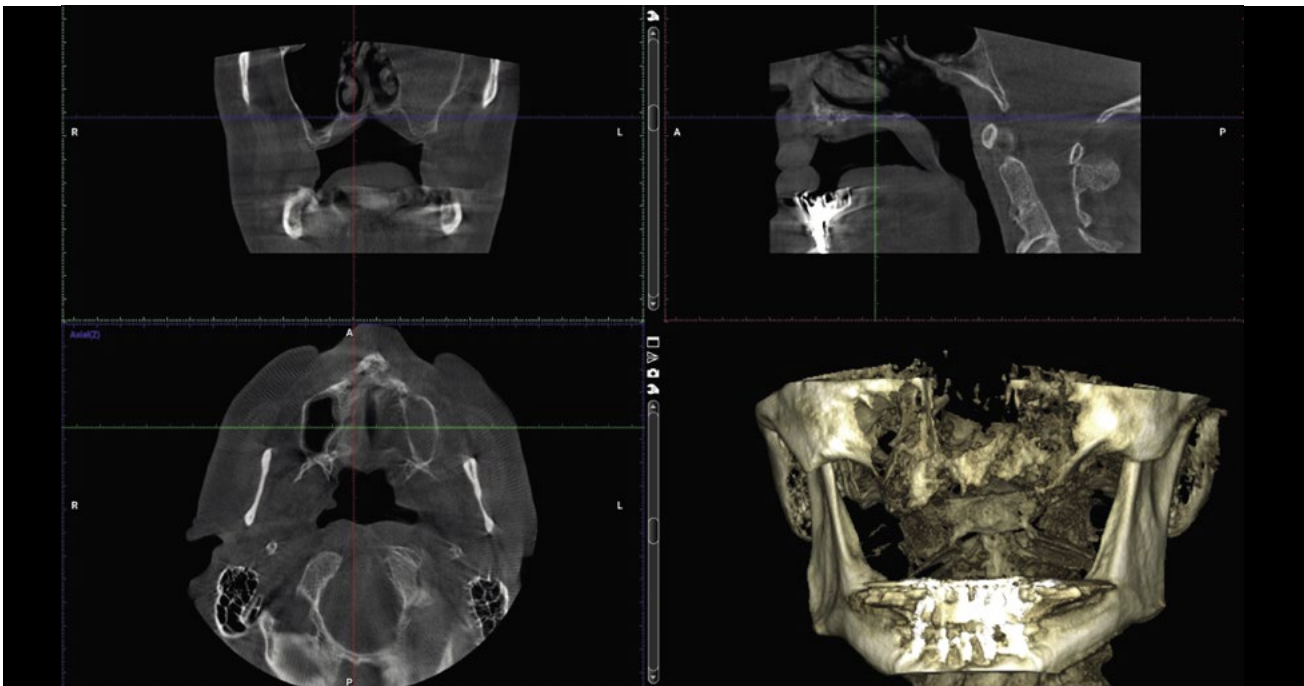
CBCT of the patient two months after extraction.
